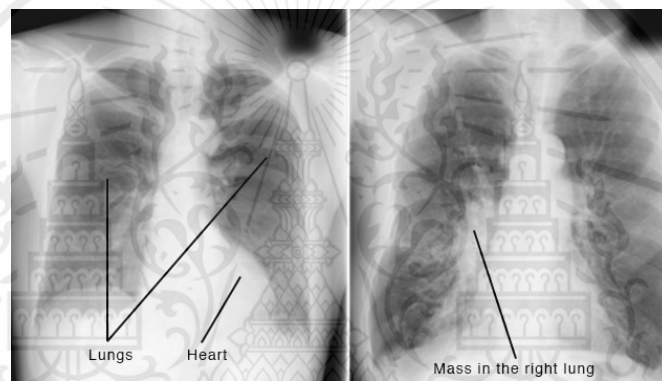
Example of chest X-Ray image
